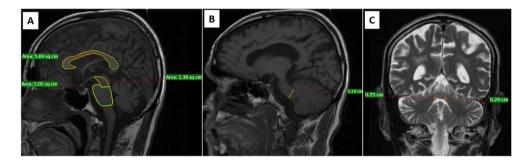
Sagittal T1-weighted MRI image of PD showing the measurement of (A) corpus callosum area (5.69 cm^2), midbrain area (1.38 cm^2), pons area (5.05 cm^2), (B) MCP width (1.19 cm), (C) coronal T2-weighted MRI image of PD showing the measurement of right SCP width (0.25 cm) and left SCP width (0.24 cm).
